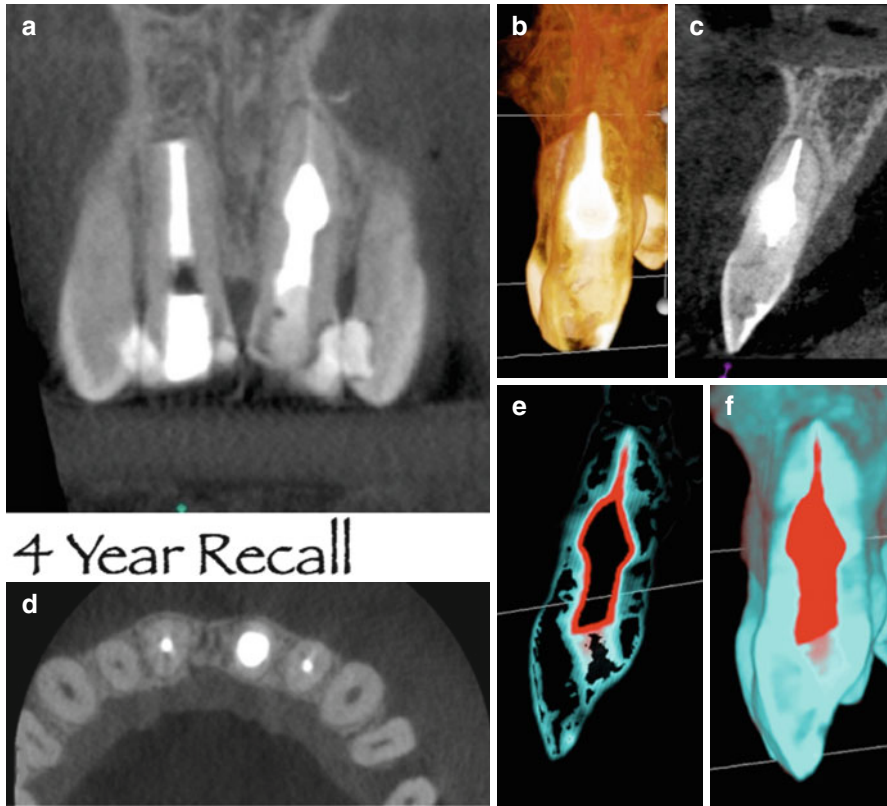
Continuation of case in Fig. 2.17: (a) Coronal view, 4-year recall of tooth number 9 and healing of previous periapical surgery on tooth number 8. (b, e, and f) are 3D reconstructions of tooth number 9. (e) and (f) are 3D templates constructed to determine the interface and adaptability of the root canal filling to the resorptive defect canal walls. (c) is a sagittal view and (d) is an axial view through the widest section of the resorptive defect
